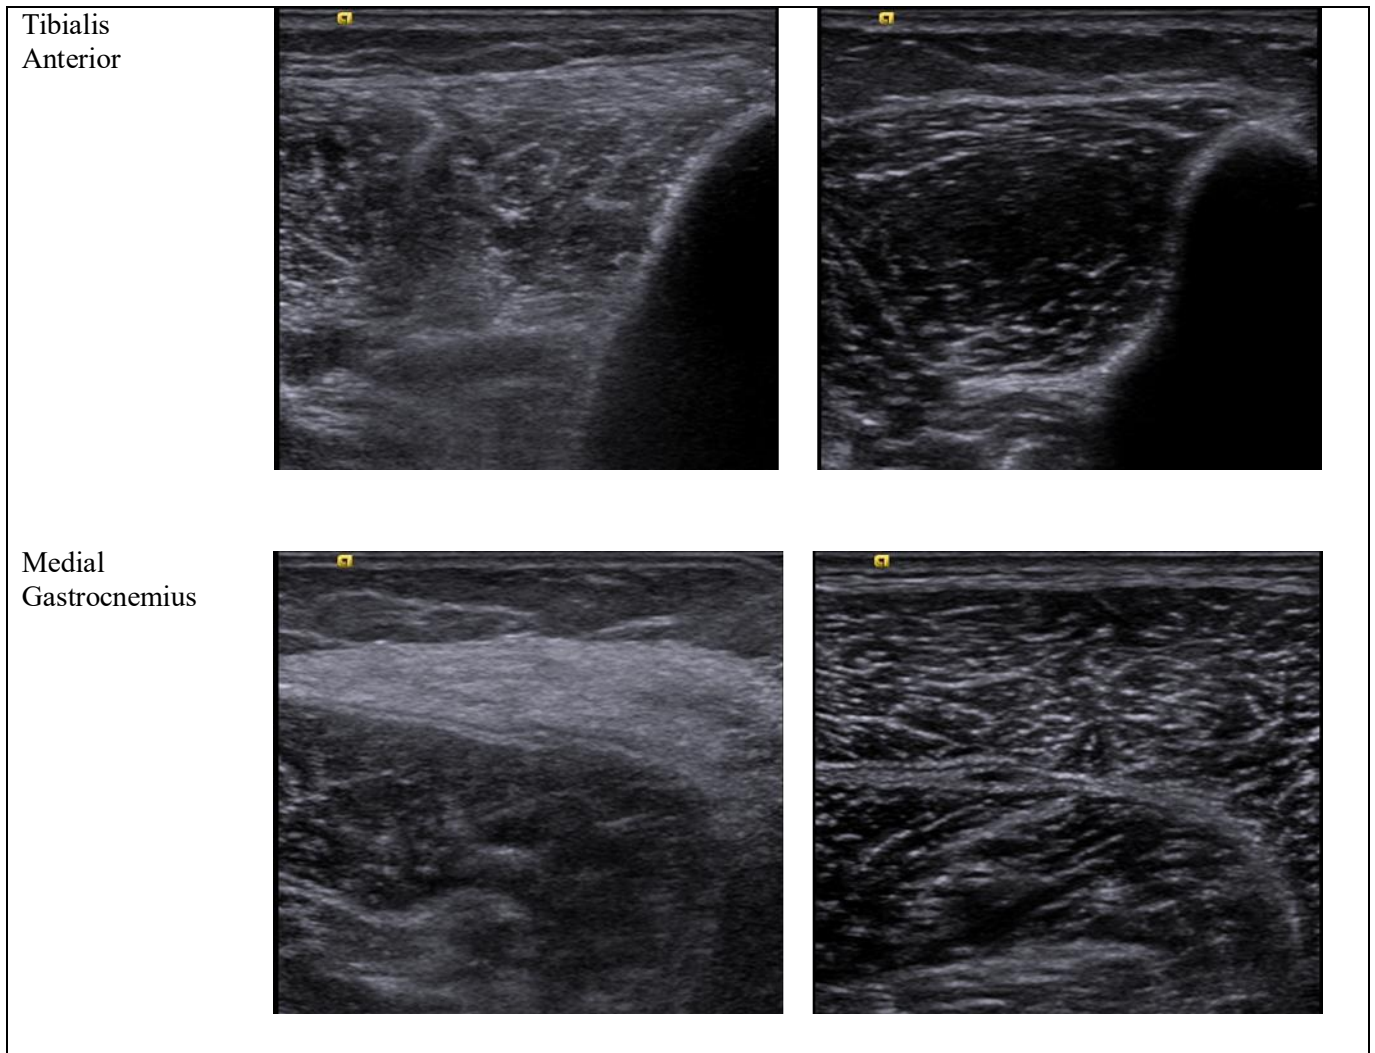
Muscle ultrasound examination showing the most affected muscles in a representative IBM patient and a control.
